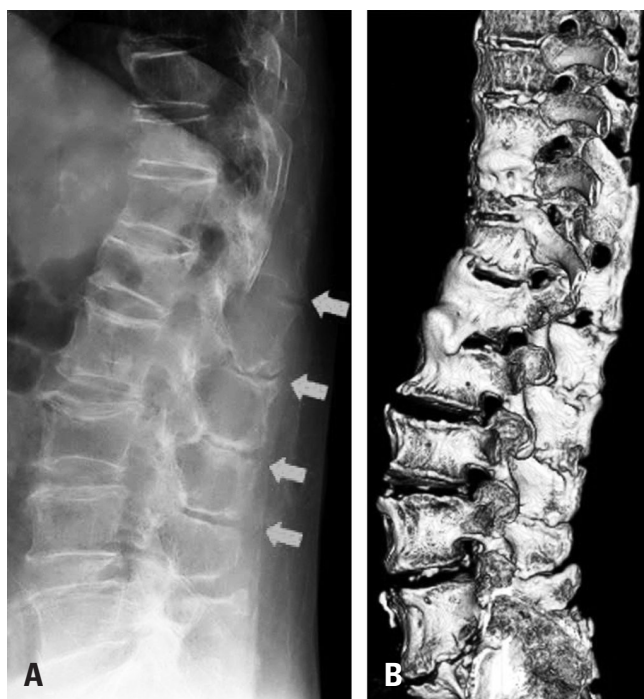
(A) Initial radiographs showing severe narrowing of the interspinous process (red arrows). (B) Three-dimensional reconstruction of computed tomography images showing Bastrup disease (kissing spine).
